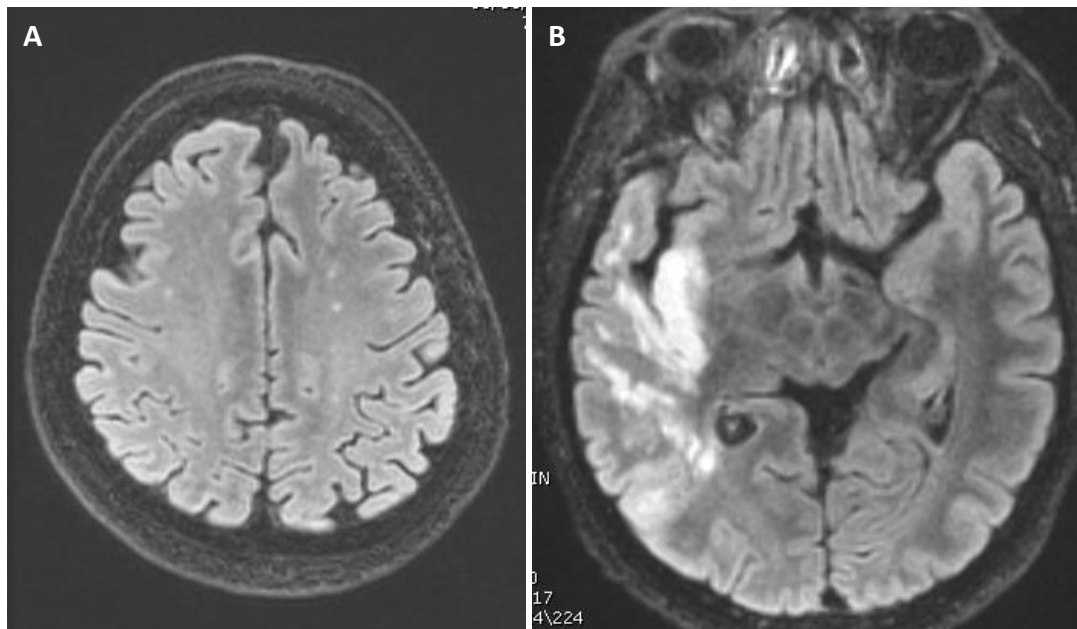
In A, FLAIR axial images of the pt 21 (female, 59 y.o.) shows only small gliotic areas in semioval centers, prevalent in the left side. In B, FLAIR axial images of the pt 19 (male, 60 y.o.) demonstrate a large post-ischemic lesion in the right temporal and insular lobes, regions included in the ROI used for the calculation of the BOLD response.
